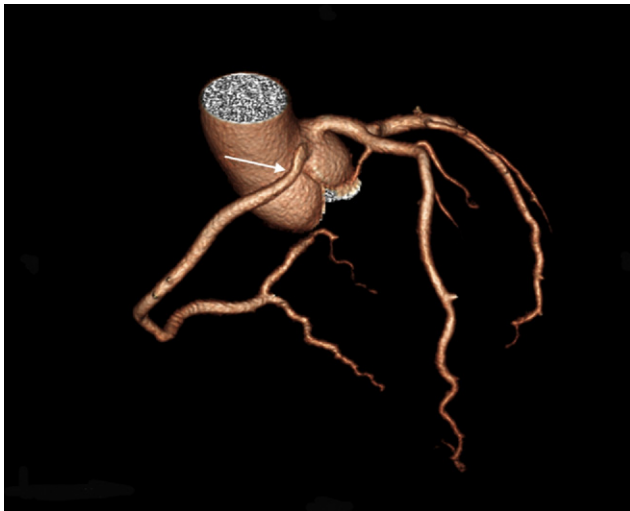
Surface rendered image of aortic root and coronary arteries obtained from a CT scan. Note the intramural course of the right coronary artery (arrow). (Color version of figure is available online.)
